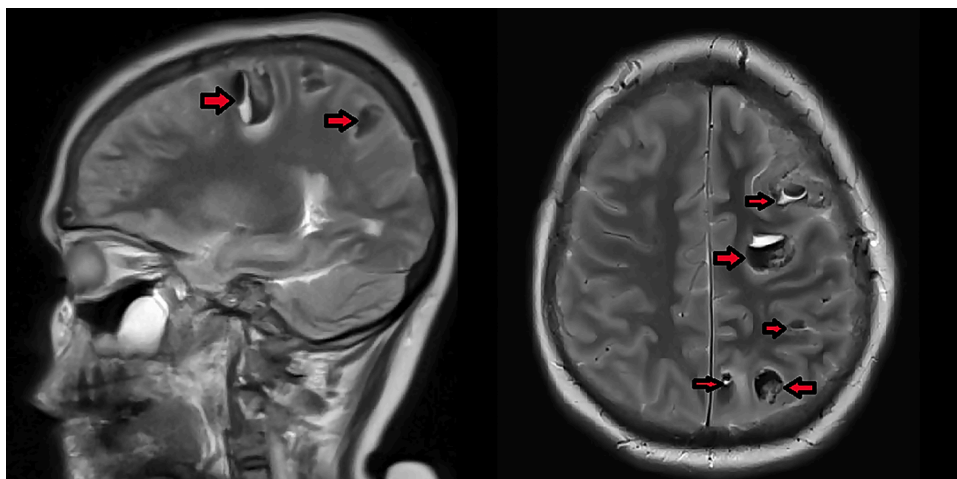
MRI brain: Multiple intra-parenchymal air pockets in the brain, remarkable for pneumocephalus.
